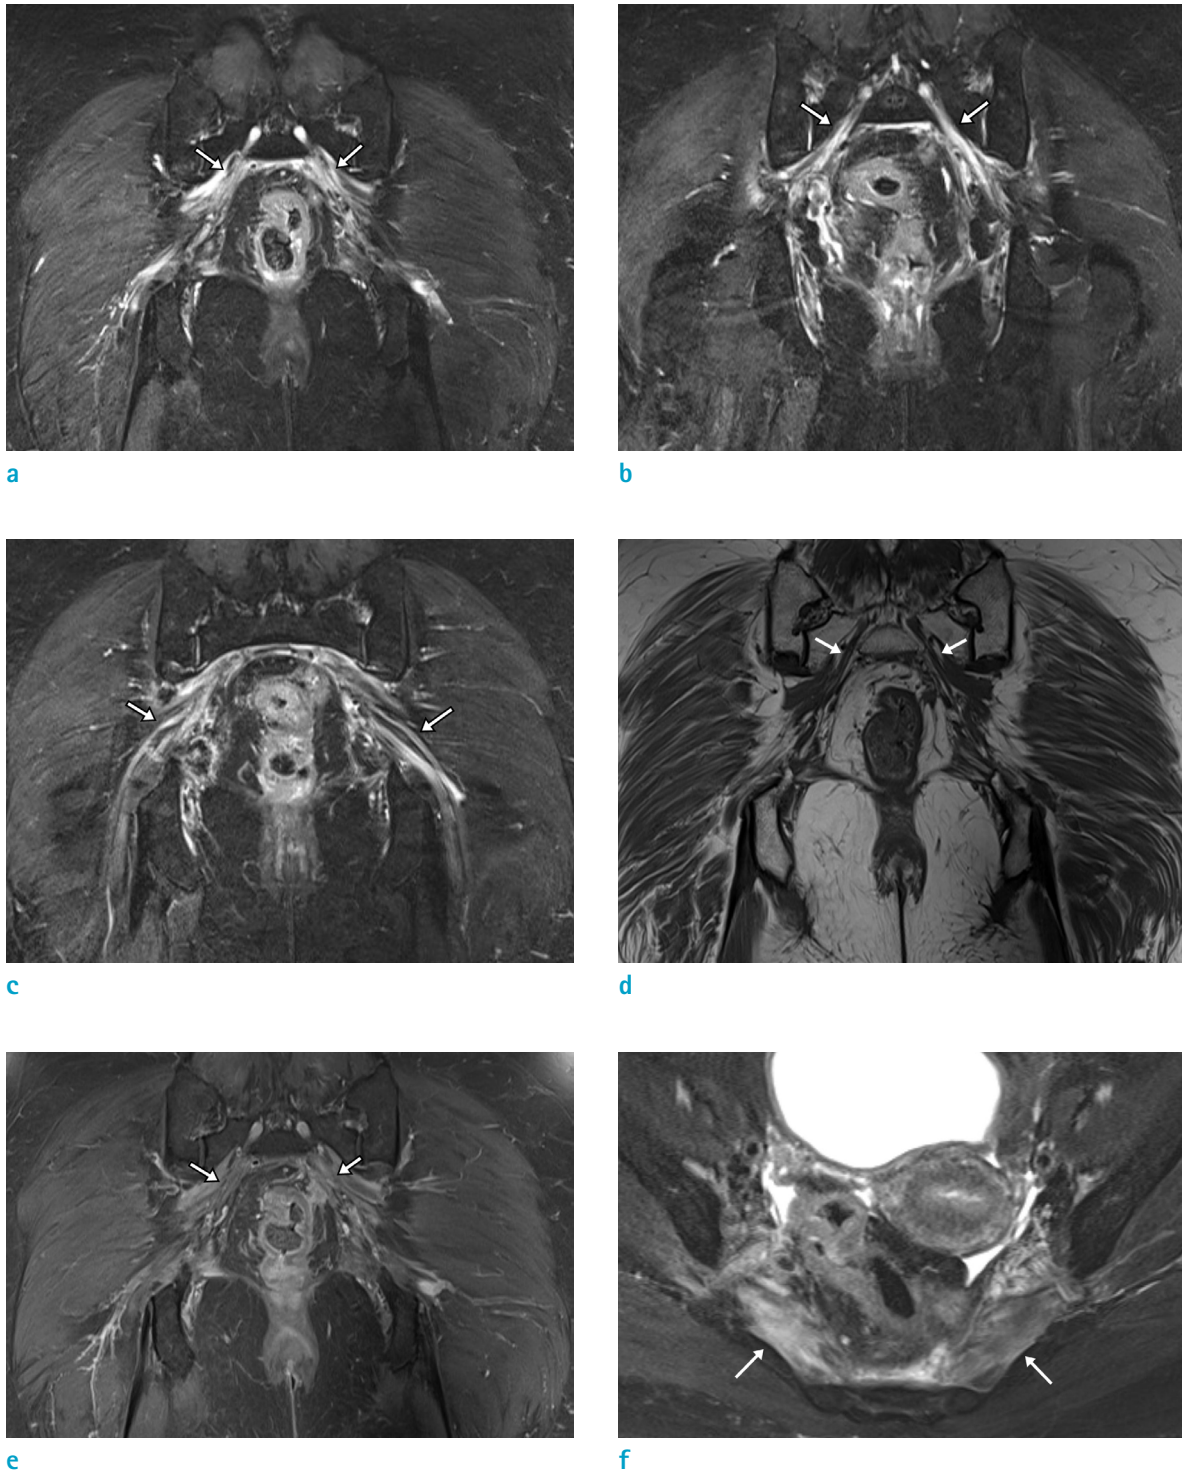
Contrast-enhanced hip MRI two years after the completion of CCRT. Coronal MRI at the first sacral foramen level reveals bilateral, symmetric, and diffuse T2 hyperintensity of LSP on coronal FS T2WI (a, arrows). The consecutive coronal FS T2WIs in the posterior direction demonstrated extensive involvement of LSP (b, c, arrows). Also, diffuse mild enhancement of the impacted LSP at the first sacral foramen level is depicted on T1WI (d, arrows) and contrast-enhanced T1WI (e, arrows). Note the asymmetric T2 signal change (pronounced on the right side) of the bilateral piriformis muscle (f, arrows). FS = fat suppressed; LSP = lumbosacral plexus
